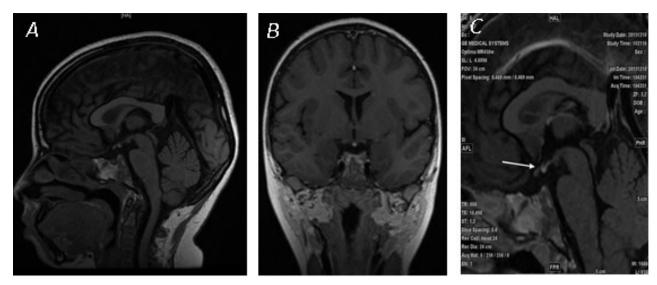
MRI T1-weighted images: (A) Sagittal, (B) Coronal and (C) Sagittal; showed spontaneous high T1 nodule at the median eminence of the third ventricle with absent normal spontaneous T1 hyperintensity of the neurohypophysis indicating ectopic posterior pituitary. The ectopic pituitary gland is pointed out in Figure 3(C).
